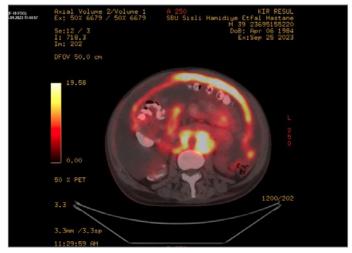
Image of involvement on peritoneal surfaces on F-18 FDG PET/CT.
